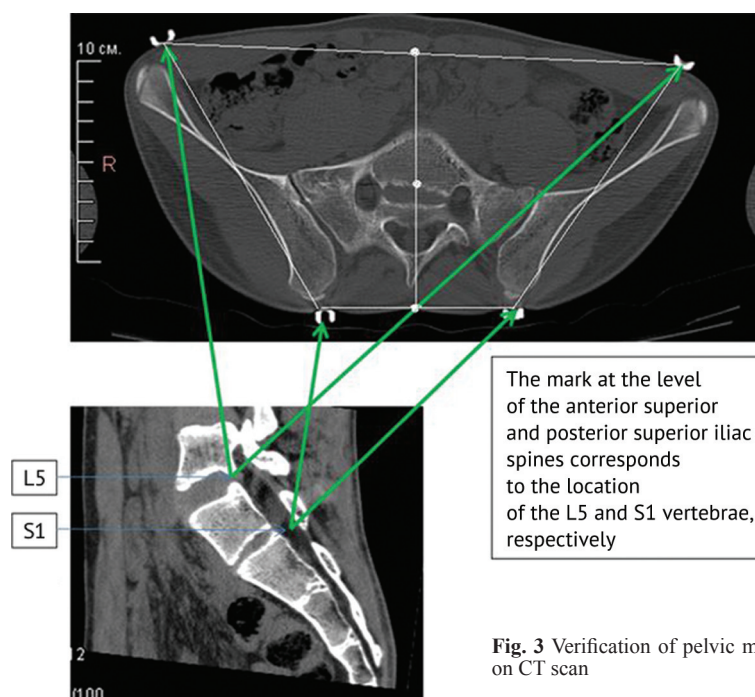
Verification of pelvic markers on CT scan
